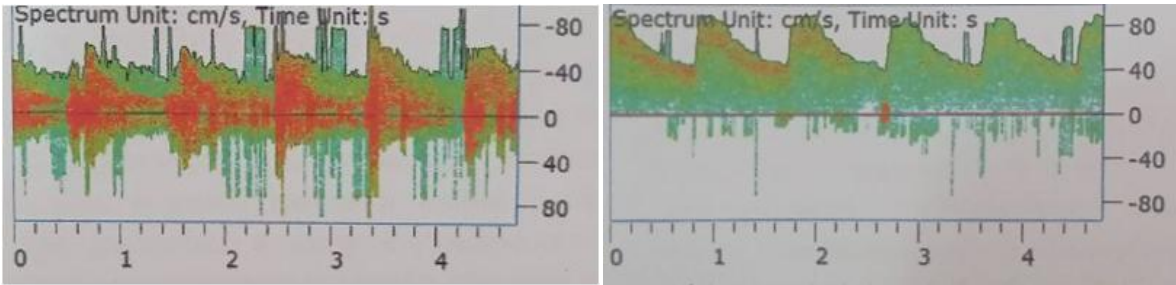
Transcranial Doppler ultrasonography of the vertebral artery. Vertebrobasilar department
